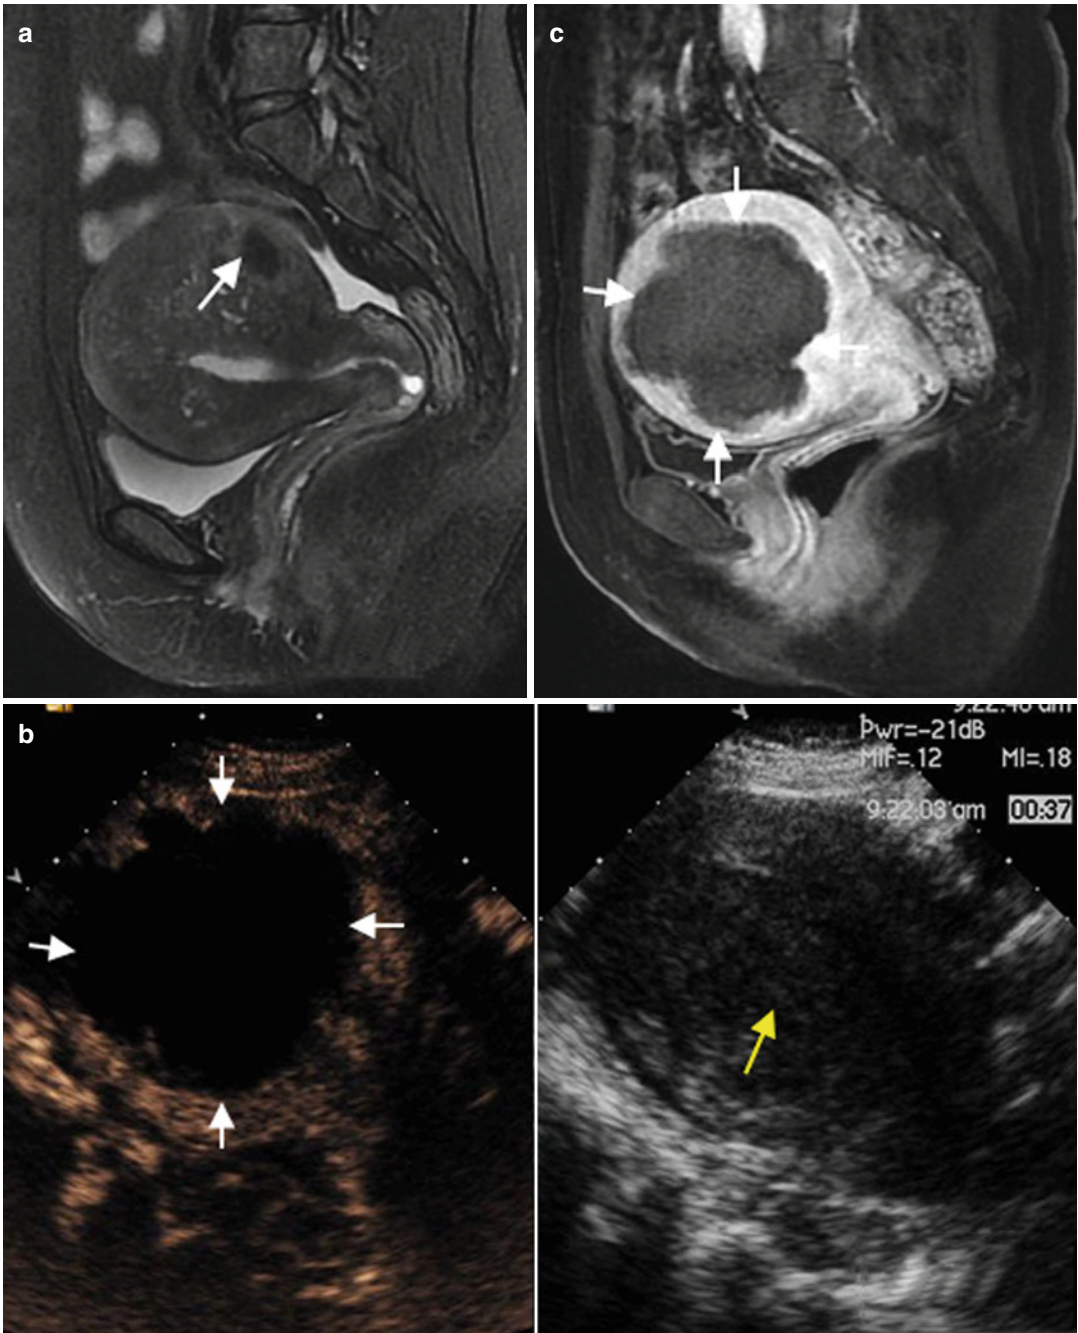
A 43-year-old woman with diffused adenomyosis. Her uterine size was 10.5 cm × 8.7 cm × 7.9 cm. (a) MRI (T2WI) before MWA, enlargement of the diffused junctional zone in the whole uterus; in the posterior wall a small leiomyoma could be found (*white arrow*). (b) After
